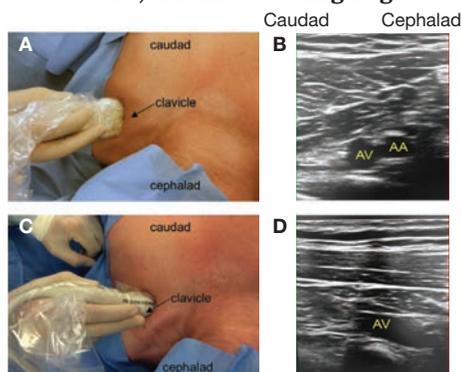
Axillary vein. (A, B) Transverse and (C, D) longitudinal position of the ultrasound probe with imaging of the left axillary vein (AV) and the left axillary artery (AA). (With permission of Denault et al. *Basic Transesophageal and Critical Care Ultrasound 1st Edition*, CRC Press Taylor & Francis Group 2016.)
